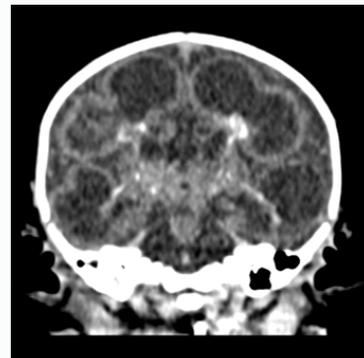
Coronal section CT brain showing cystic lesion with periventricular hyperdensities.
